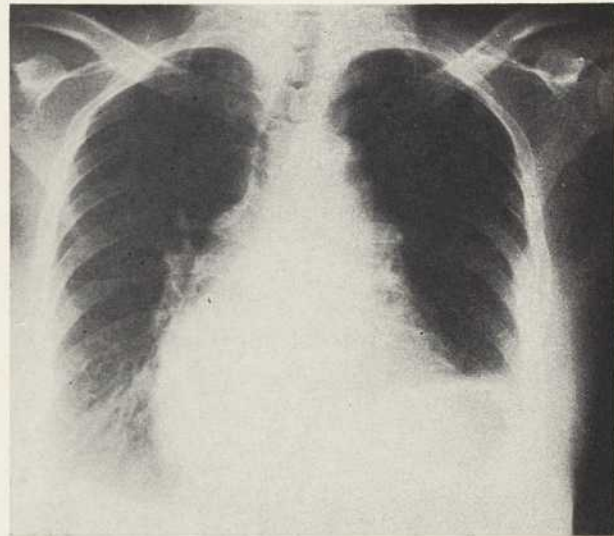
X-ray chest from the same patient and at the same time as Figure 11. The left diaphragm is elevated due to phrenic nerve paralysis (surgical trauma). The donor heart appears to be enlarged but the lung fields are clear.
